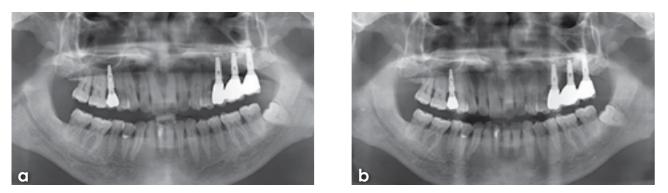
(a) Panoramic view after delivering the prosthesis in 2006. (b) Seven years later, reoperative radiograph showing a severe vertical peri-implant defect around the implant positioned at the maxillary left first molar.
